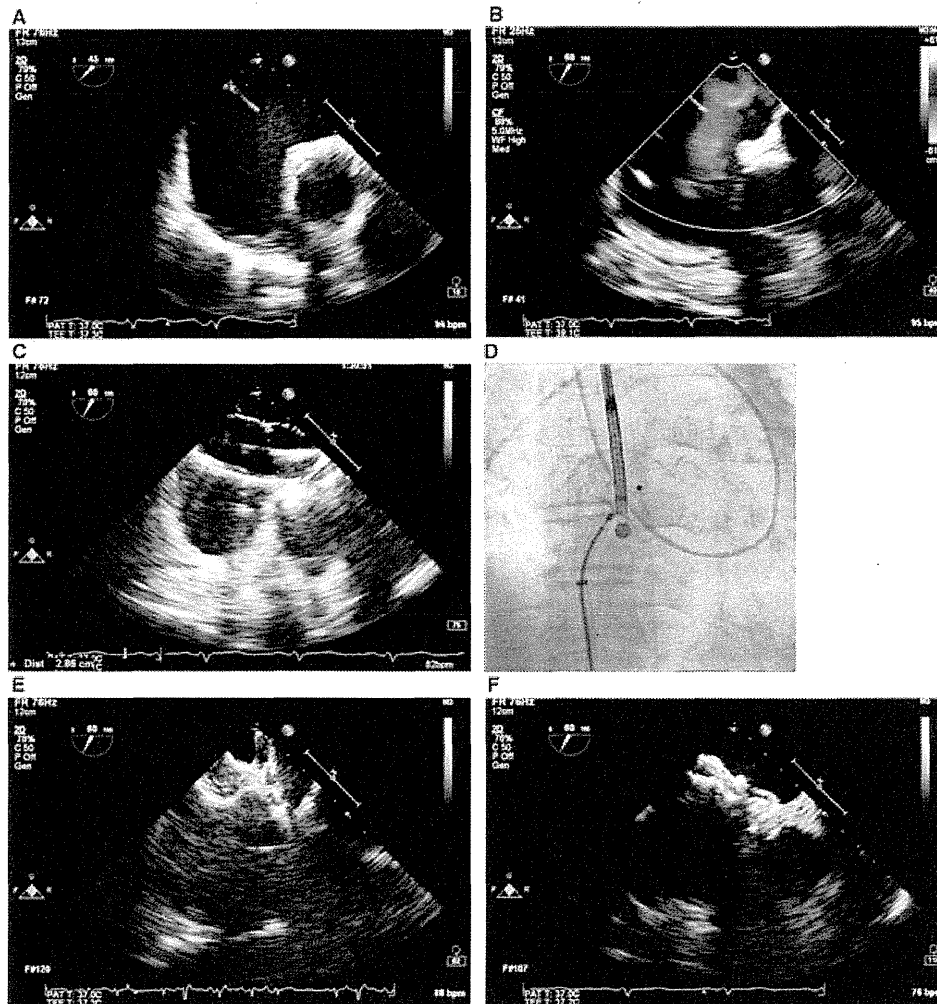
Transcatheter atrial septal defect closure under micro-TEE and fluoroscopic guidance. A. Micro-TEE demonstrates a large atrial septal defect (ASD) and a deficient superior-anterior rim. B. With color Doppler image, left-to-right shunt flow is recognized. C. Balloon sizing using the stop-flow technique. D. Fluoroscopic view and E. micro-TEE view deploying a 30-mm AMPLATZER Septal Occluder. F. Device is deployed successfully.
